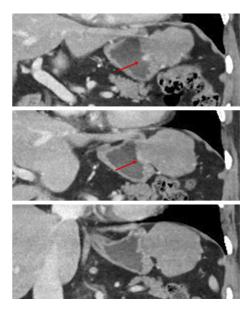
Coronal contrast-enhanced computed tomography. An irregularly shaped tumor 60 mm in diameter on the serosal side of the stomach. The enhanced mucosal side of the tumor suspected of being vascular-enriched gastric submucosa.
